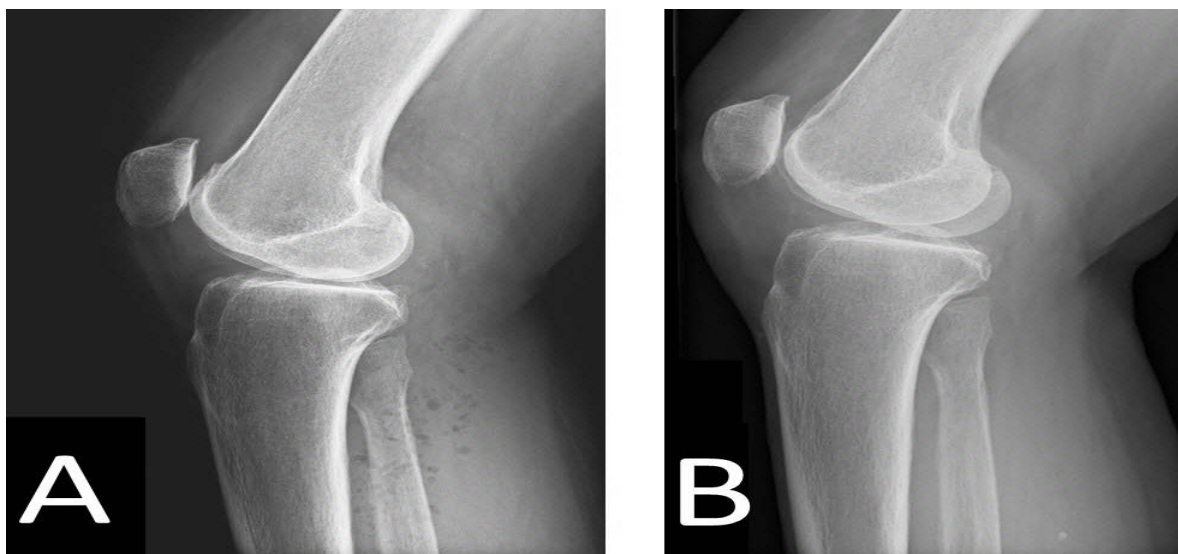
(A) Lateral radiographic view of the right knee showed multiple soft tissue gas projected over the posterior aspect of the proximal tibia-fibula. (B) Follow-up radiograph performed 9 months later showed complete resolution of soft tissue gas.
